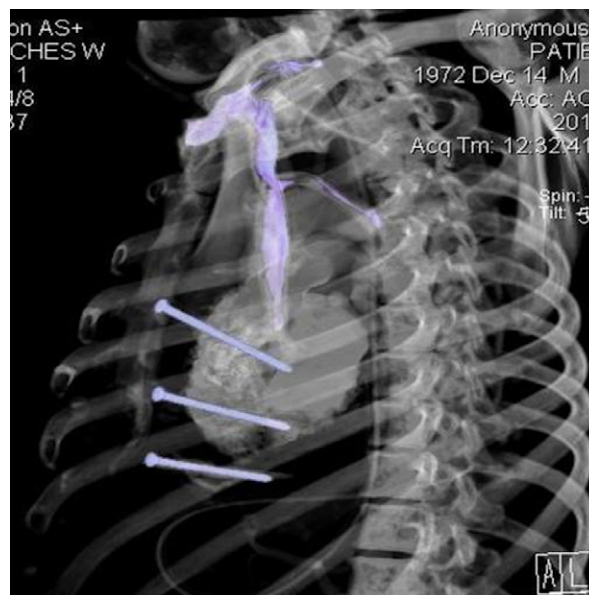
Patient 2. Computed tomogram (3-dimensional reconstruction) shows the penetration of 2 nails across the ventricular septum.
